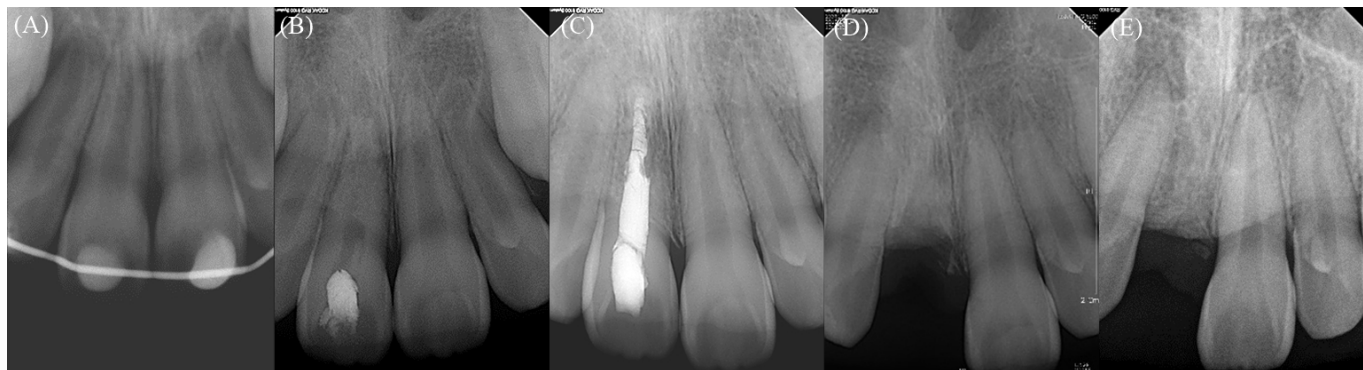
The radiographic view of #11. (A) post replantation; (B) after 2 months of follow-up; (C) after 1 year and 7 months of follow-up; (D) after decoronation; and (E) 4 years after decoronation.
